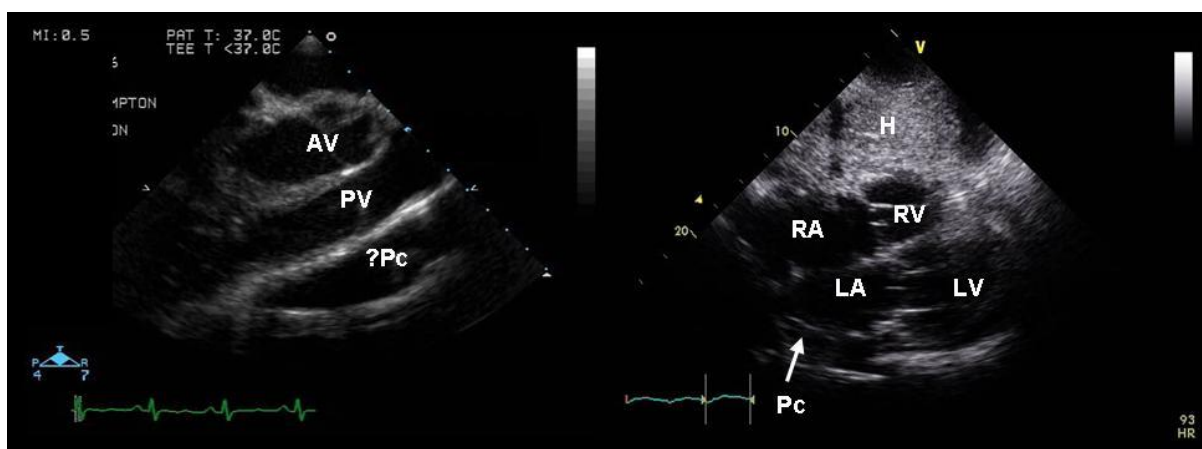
Some pitfalls in the diagnosis of pericardial collection and tamponade. In the figure on the left (taken from a trans-oesophageal echocardiogram-TOE) there is clearly an echo-free space between what appear to be two layers of pericardium, suggesting a pericardial collection (?Pc). This is, however an artefact, due to the very bright pericardium next to the very black blood. In the image on the right (subcostal view) there is a small pericardial collection (Pc, arrowed), unusually positioned posterior to the left atrium (LA). Although small, this was causing profound haemodynamic compromise, as it had accumulated rapidly following a percutaneous coronary intervention.
